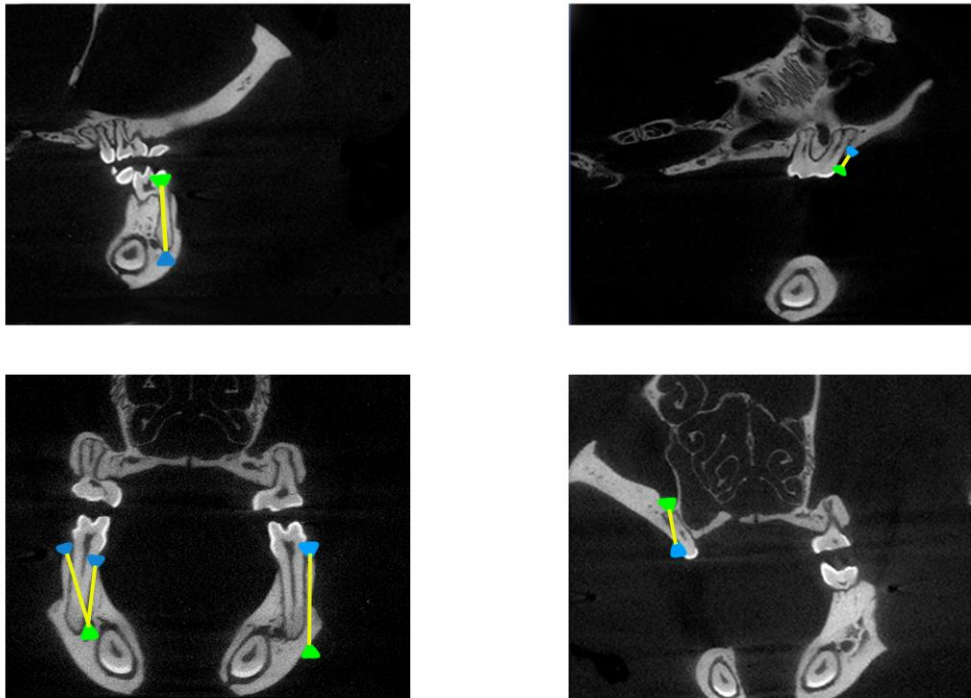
Measurements carried out from 2D μ CT sections.
